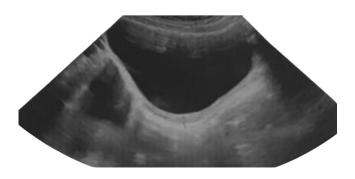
Ultrasound findings revealed uterine hypoplasia and unicornuate uterus with a rudimentary horn.
